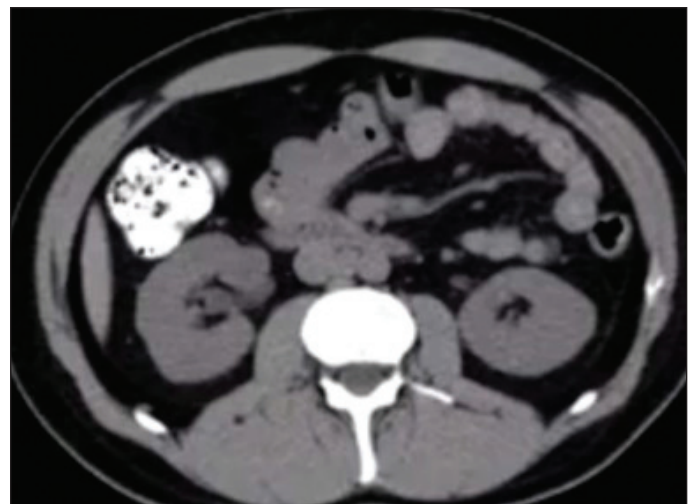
Case 4: Stage 2A seminoma. Computed tomography demonstrating 1.8 cm inter-aortocaval node.
